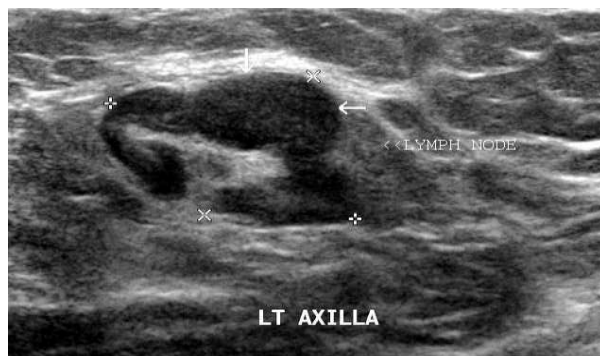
Ultrasound Axillary Examination
